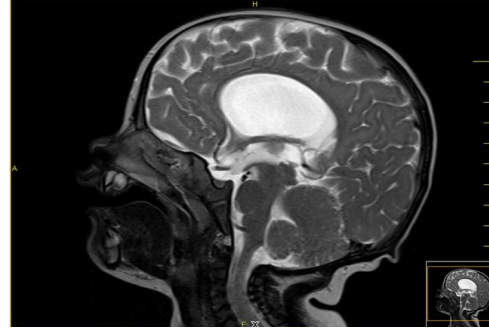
Sagittal MR image (T2 Weighted) showing thin corpus callosum.
